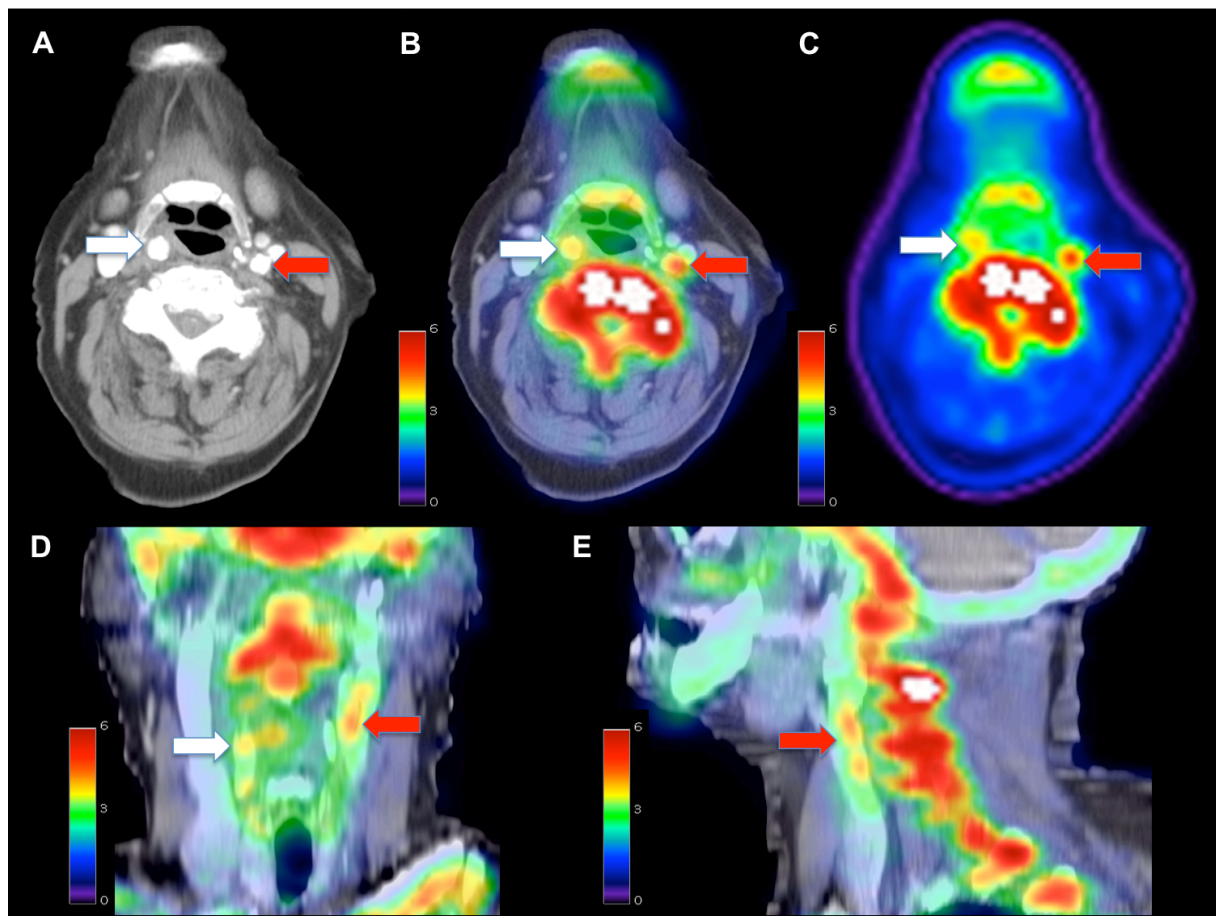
NaF uptake in symptomatic disease. (a) axial CT angiogram, (b) axial NaF-PET/CT, (c) axial PET, (d) coronal NaF-PET/CT, (e) sagittal NaF-PET/CT showing an asymptomatic right carotid artery (white arrow) and a symptomatic left carotid artery (red arrow).
